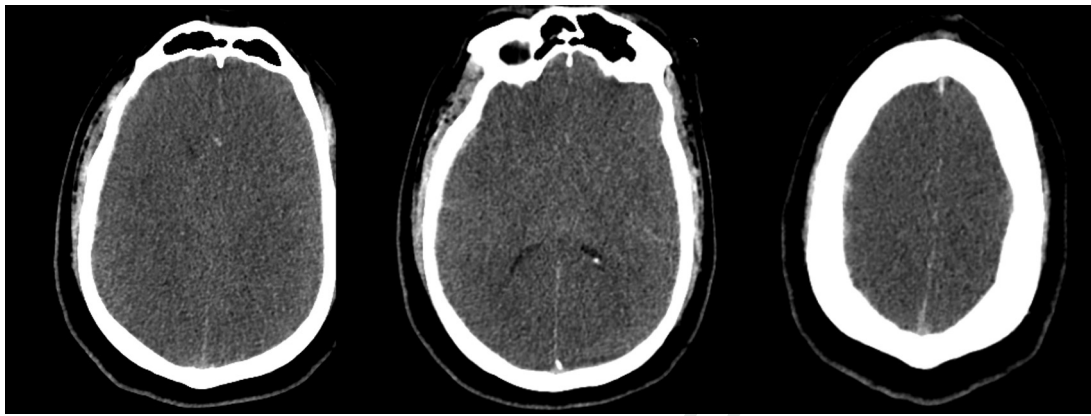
CT image of patient who had come off their motorbike at high speed. Emergency services found him to be in cardiac arrest. Note, while there is clear hypoxic brain injury and swelling effacing the ventricles, there is little or no obvious parenchymal injury. Sometimes these CT scans are reported as DAI, but hypoxia may be of greater significance.
